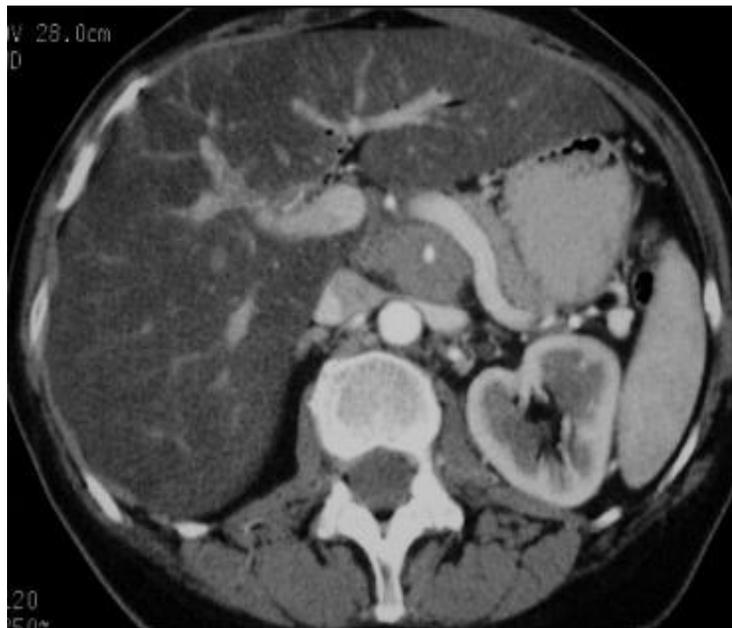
The CT criteria used to define a potentially resectable pancreatic cancer (*Kloppel et al., 2011*).
